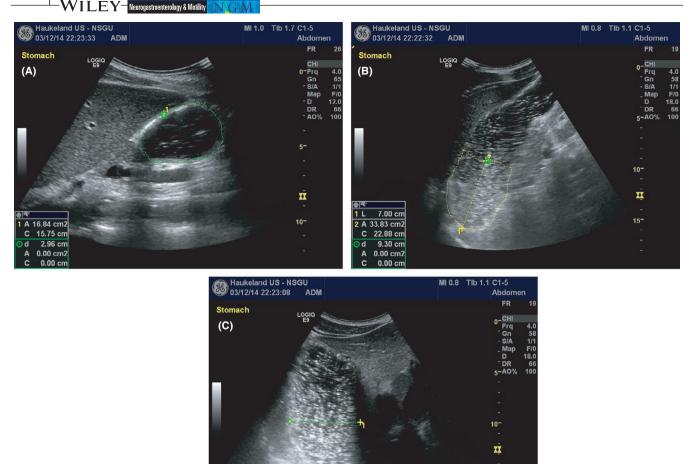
Examples of the ultrasound images obtained from the standardized sections used in the study. All images were obtained with the patient seated, after ingesting 500 ml soup: (A) Sagittal section of the antrum, using the aorta and superior mesenteric vein as landmarks. The liver is visible to the left. (B) The proximal diameter of the stomach was obtained from an oblique frontal section. (C) The proximal area was estimated from a sagittal section in the epigastrium near the midline, tilting the probe slightly upwards and to the left. The area was calculated after measuring 7 cm from the apex
